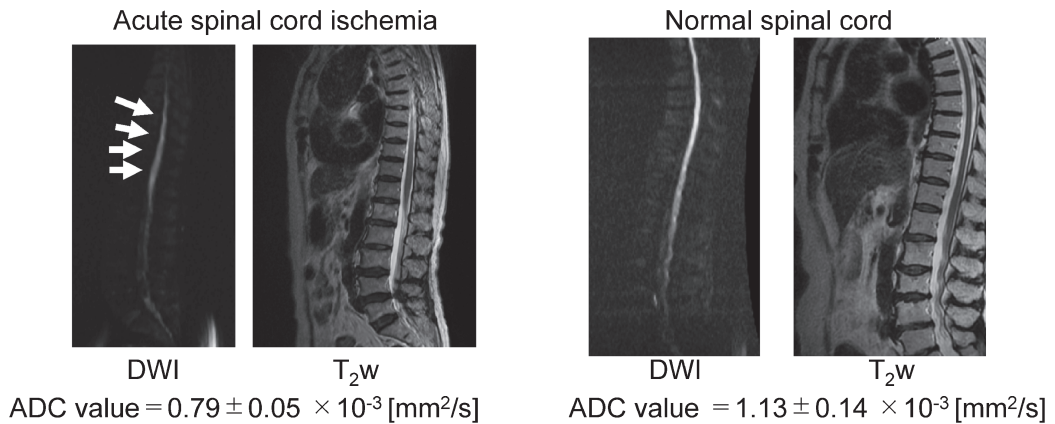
Differences in ADC values among the patients with a normal spinal cord and acute spinal cord ischemia. The DWI high-intensity signal is indicated by the arrows. On DWI, acute spinal cord ischemia is more commonly observed than normal spinal cord ischemia. Moreover, acute spinal cord ischemia does not exhibit a high intensity signal on T₂-weighted imaging.
